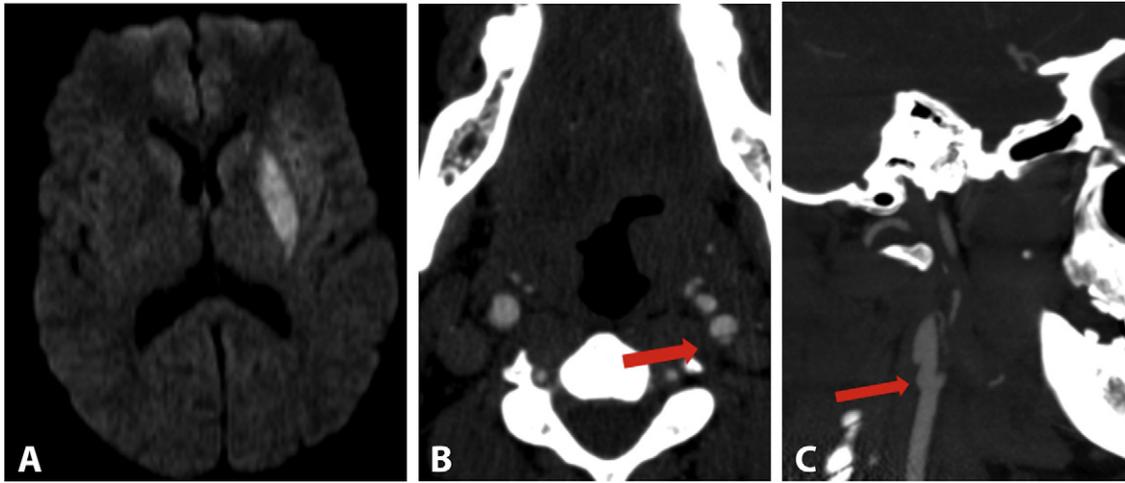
DWI imaging (A) of a 48-year-old female (patient 1) presenting with right-sided hemiplegia and aphasia shows an acute infarct in the left lentiform nucleus. Sagittal (B) and axial (C) CTA neck imaging, of the same patient showed a focal intraluminal filling defect arising from the posterior wall of the left carotid bulb compatible with a carotid web. No other stroke risk factors were identified.
